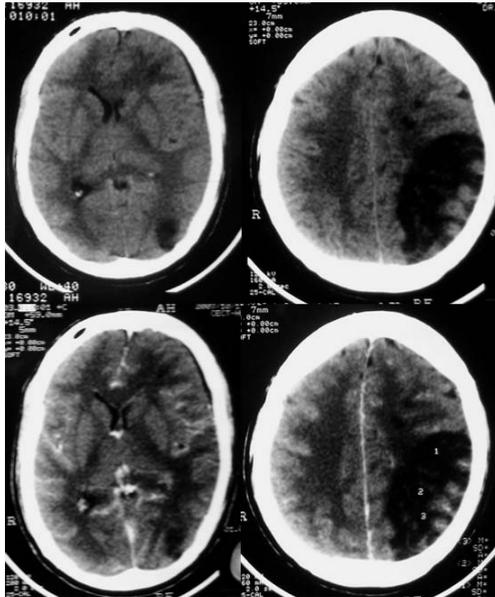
CT scan plain (upper images) and contrast (lower images) showing this subdural empyema left fronto-parietal region and large venous infarct involving left parietal lobe with gyral enhancement. Also note the associated oedema and mass effect.
